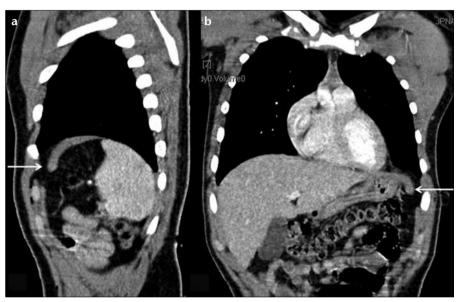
a, b. Sagittal (a) and coronal (b) reformatted CT images show retraction of the cut edges of the left hemidiaphragm, with thickening and inward curling at the site of rupture *(arrows)*, suggestive of the dangling diaphragm sign.
